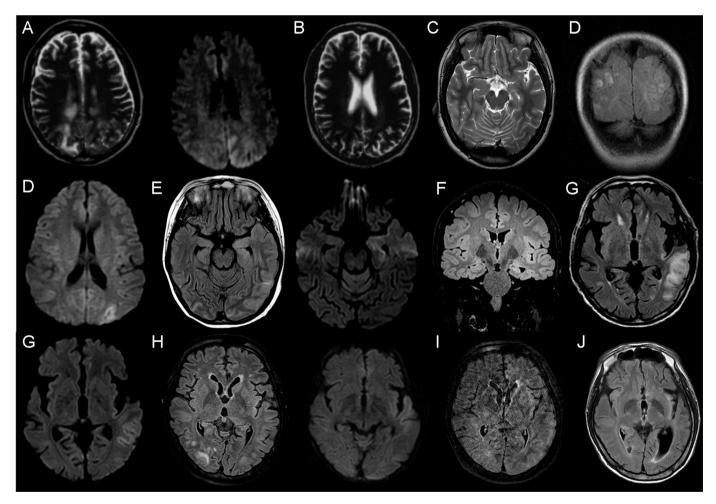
Brain magnetic resonance images (MRIs) during the acute period and follow-up. (A) T2-weighted and diffusion-weighted (DW) images of Patient 1 with posterior reversible encephalopathy syndrome (PRES). Reproduced from reference [11] with permission from Karger. (B) T2-weighted image of Patient 1 after the development of epilepsy. Reproduced from reference [11] with permission from Karger. (C) T2-weighted image of Patient 2 after the development of epilepsy. (D) Fluid-attenuated inversion recovery (FLAIR) and DW images of Patient 3 with PRES. (E) FLAIR and DW images of Patient 4 after the development of epilepsy. (G) FLAIR and DW images of Patient 5 with PRES. (H) FLAIR and DW images of Patient 6, 24 days after the initial MRI. (J) FLAIR image of Patient 6, 2 years after the initial MRI. See Tables 1 and 2, and text for information.
